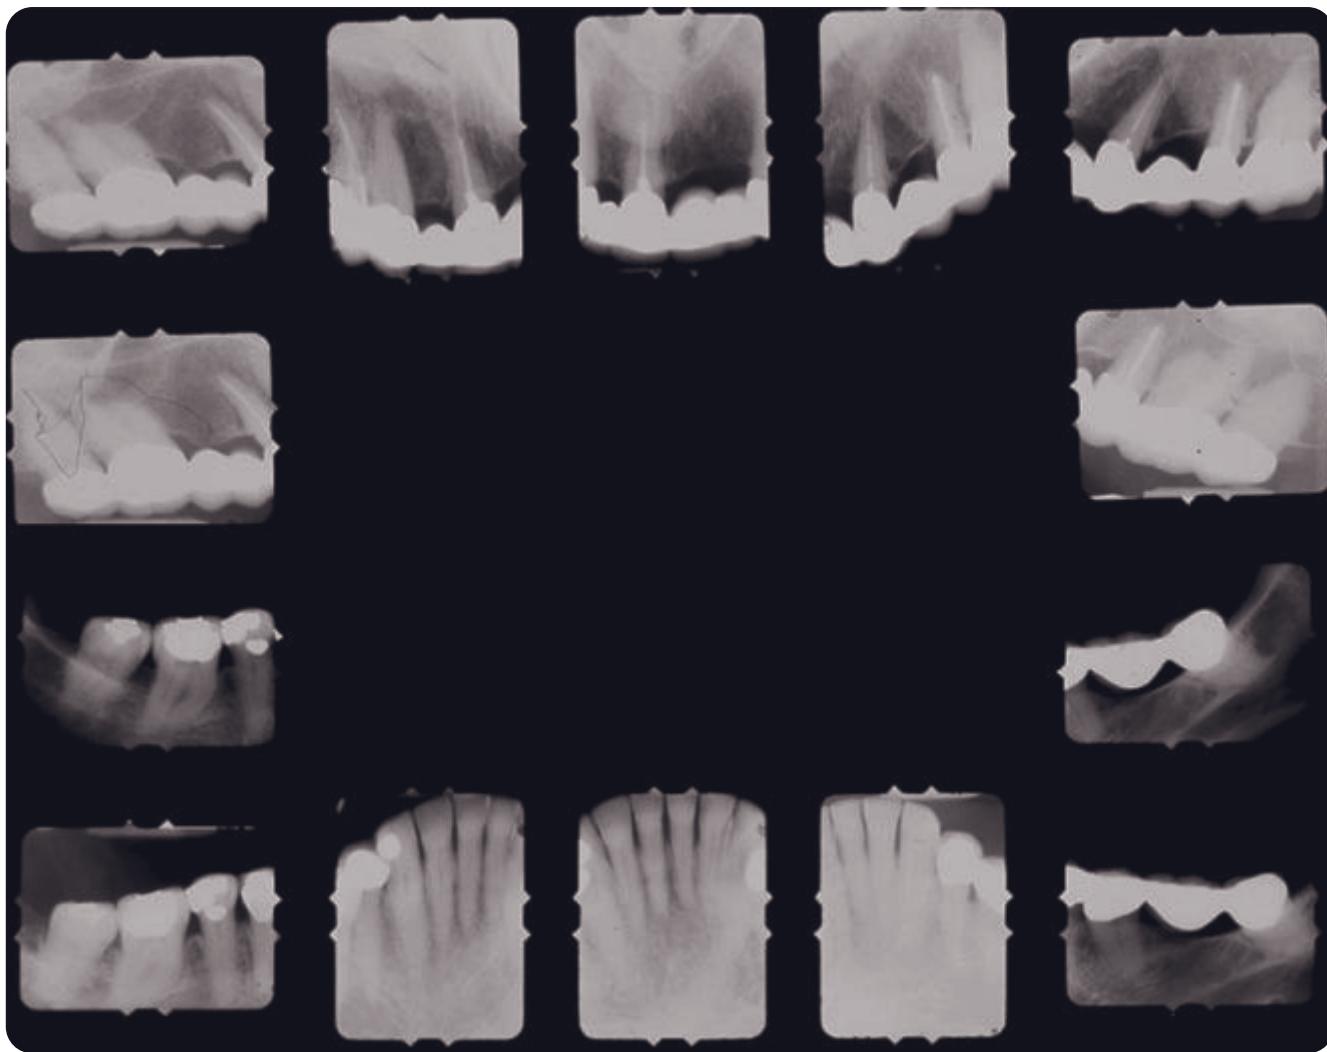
Pretreatment radiographs. Multiple endodontics on anterior teeth with narrow, tapered roots can make structural prognosis somewhat guarded.
